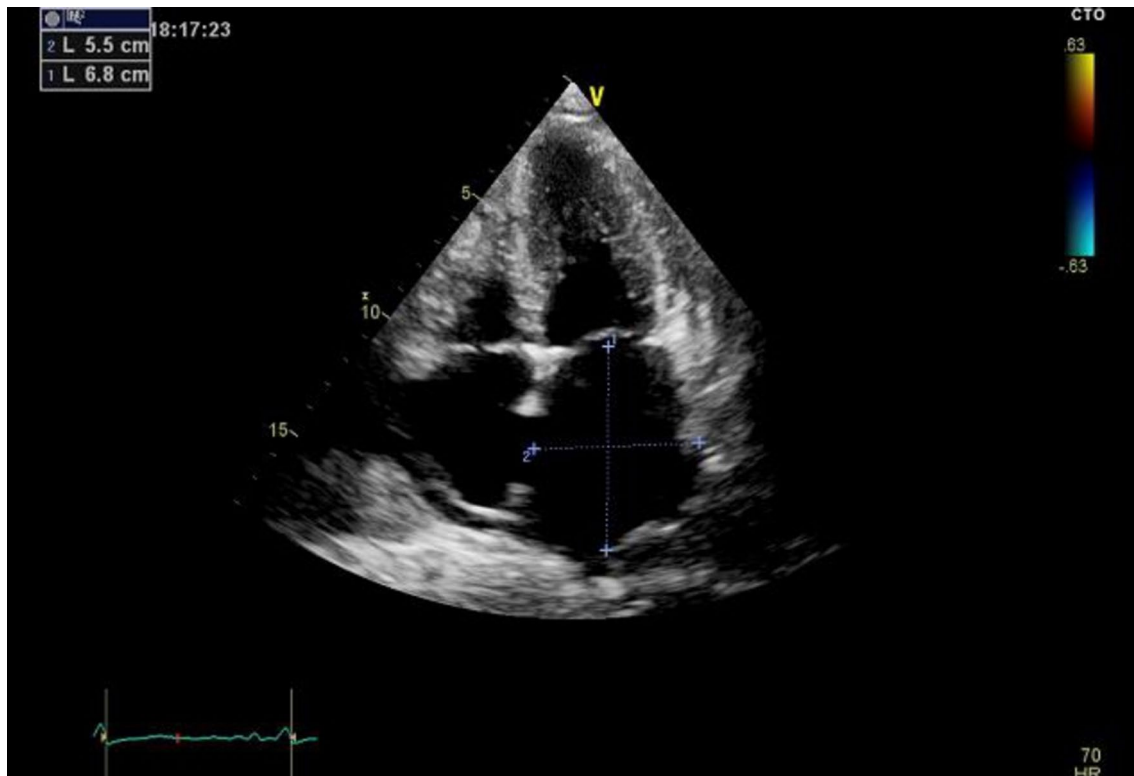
Echocardiographic measurement of left atrial sphericity index (LASI). The measurement is calculated from the apical 4-chamber view as the ratio between the transverse and longitudinal diameters, excluding the left atrial appendage and the insertion of the pulmonary veins
